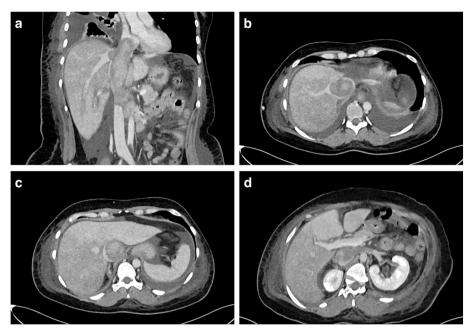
Contrast-enhanced computed tomography scan: a the thrombus in the IVC extending to the right atrium and to the renal veins; b and c with diffuse patchy enhancement due to hepatic congestion and necrosis; d with thrombus in the renal veins
